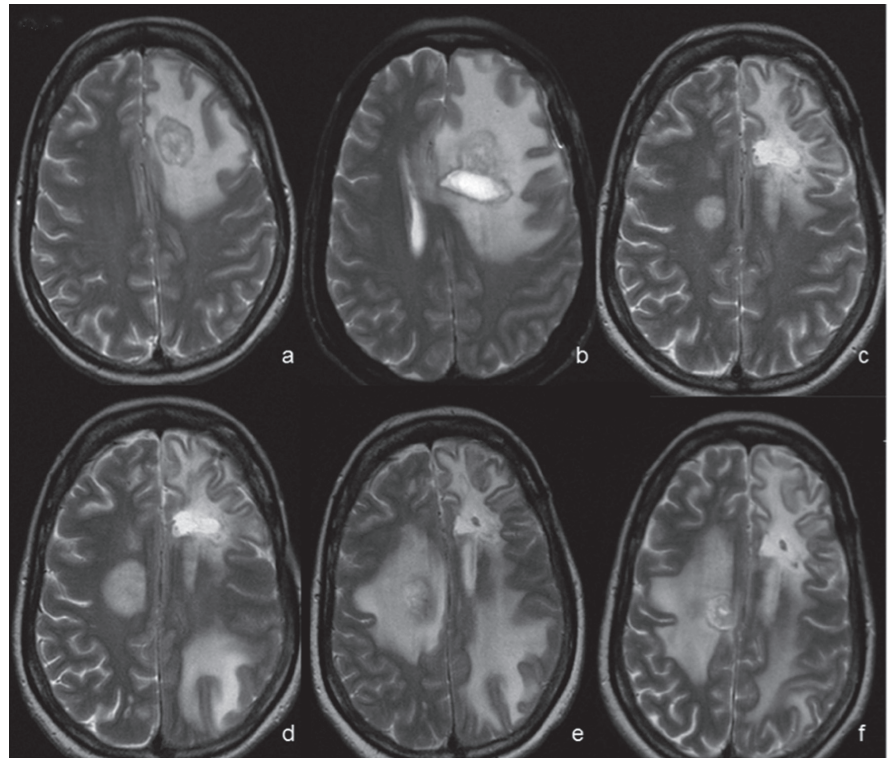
MRI follow-up of brain lesions. T2-weighted images.
